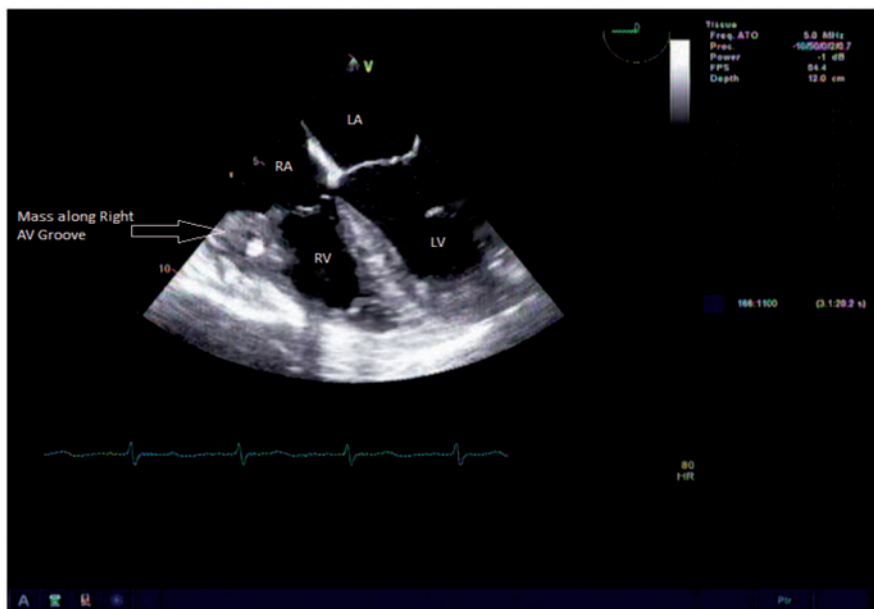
Transoesophageal echocardiography showing mass in the right atrioventricular groove.
